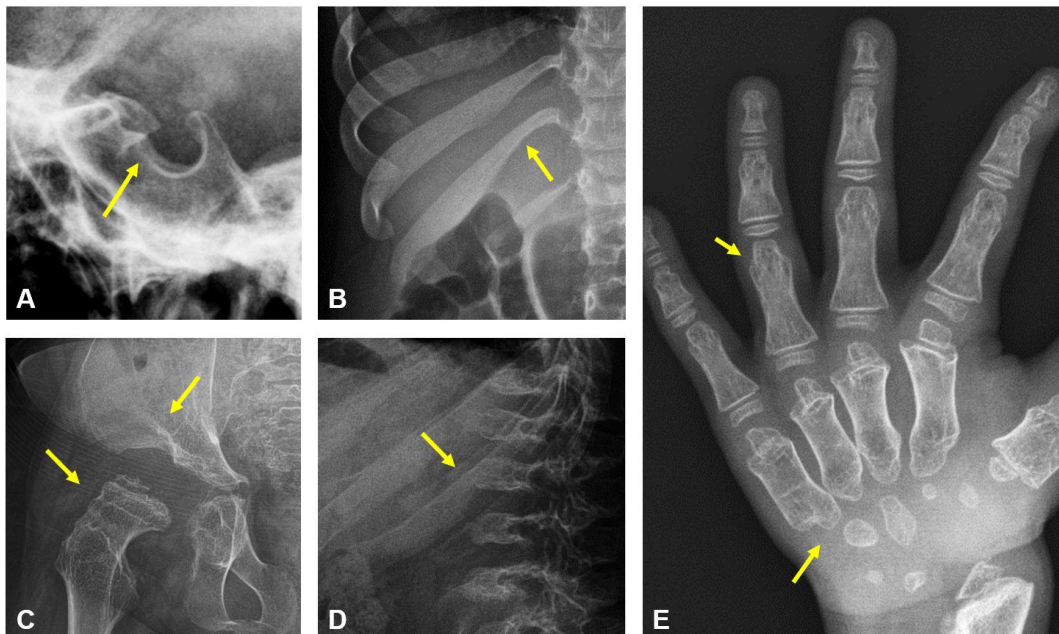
Dysostosis in mucopolysaccharidoses (MPSs). (A) and (B) are images of a patient with MPS type II, (C, D), and (E) are images of MPS type IV patients [(C) and (D) are images of the same patient]. The following radiographic findings can be identified in each image; (A) J-shaped sellar turcica, (B) oar-shaped ribs, (C) beaking of vertebral bodies, (D) flared iliac wings and dysplastic femoral head, (E) bullet-shaped proximal phalanges, central pointing of the proximal metacarpals.
